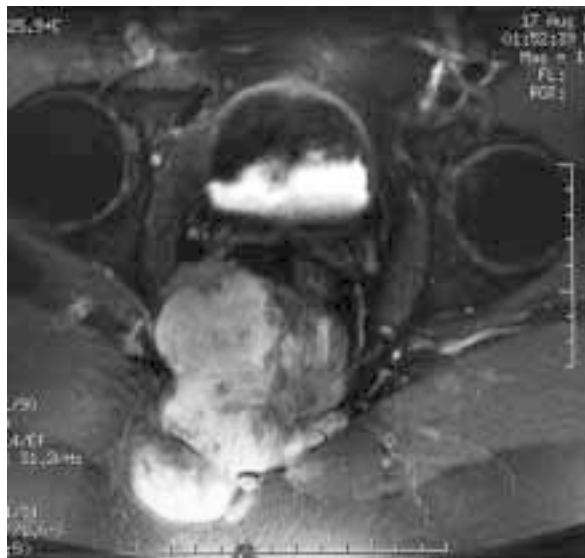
Enhanced axial T1-weighted MR image taken 3 cm cranial to Fig. 1a.
